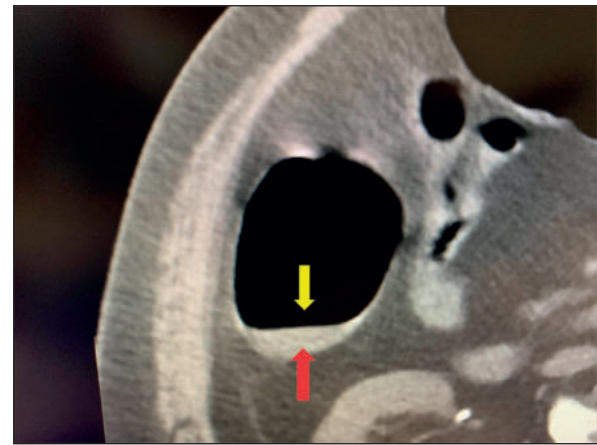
Spiral CT scan of the mediastinum and lungs, 3D reconstructions. Tissue lesion and bilateral basal and dorsal pulmonary fibrosis – COVID-pulmonitis
